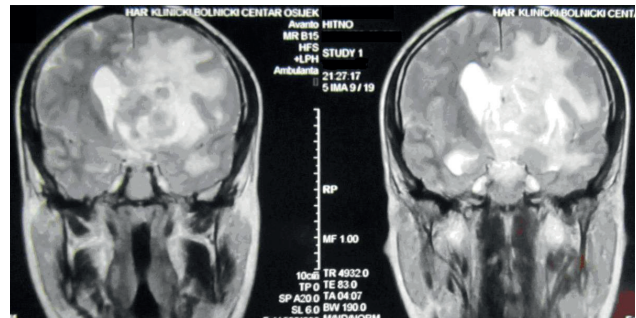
Preoperative brain MRI (T2-weighted image, coronal reconstruction) demonstrating solitary, lobular, partially cystic intraventricular tumor.
